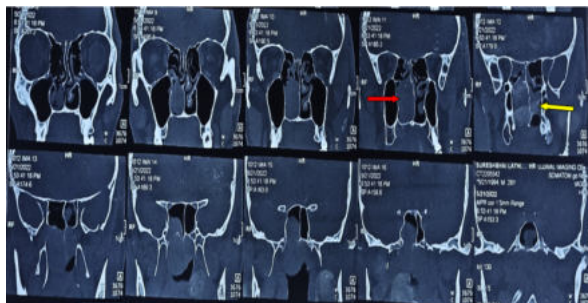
CT-Scan of Paranasal Sinuses with axial view: Red arrow showing mass (Juvenile nasopharyngeal angiofibroma) in right nasal cavity and yellow arrow showing extension of mass in nasopharynx blocking the left sided Choana posteriorly.
